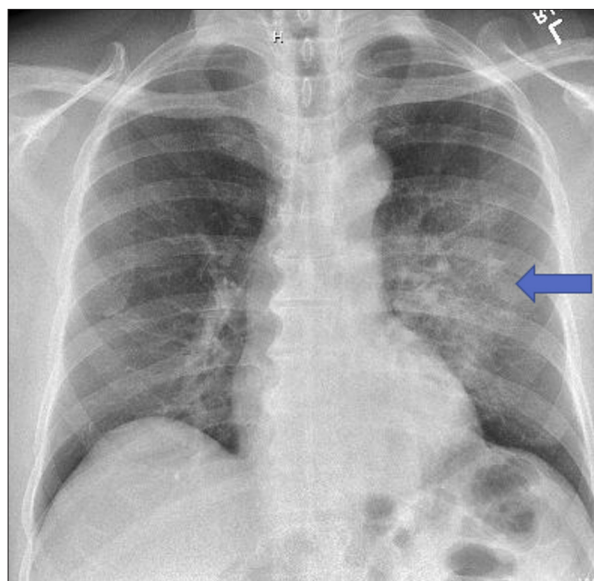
Chest X-ray on initial presentation. Hazy left perihilar opacities indicated a likely diagnosis of atypical bacterial pneumonia.
